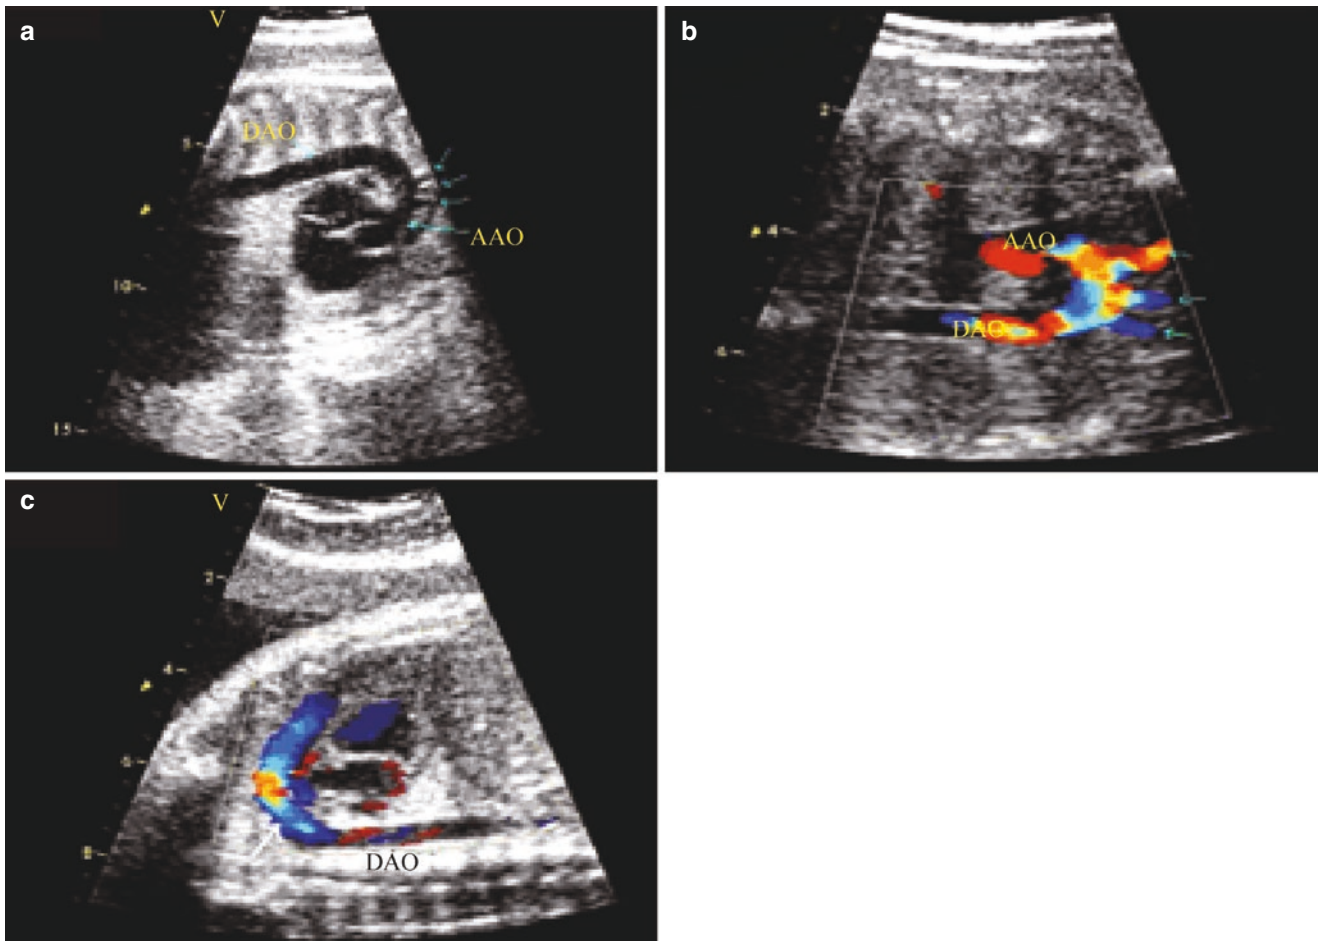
Long-axis view of fetal ductal and aortic arch. (a) 2-D imaging of the fetal aortic arch in the prone position, arrow shows the three brachiocephalic arteries; (b) Color Doppler imaging of the fetal aortic
